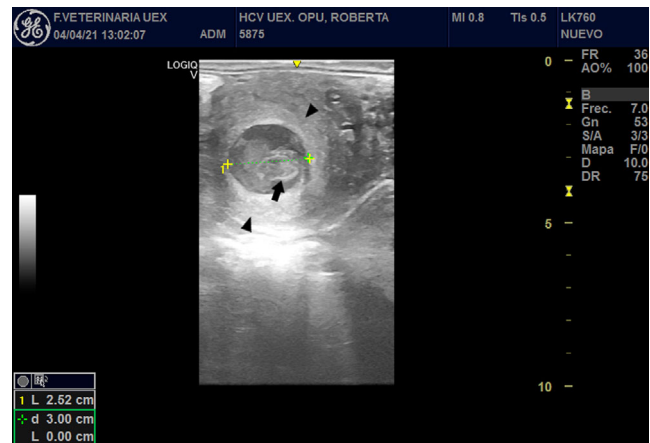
Transrectal ultrasonographic image of the left ovary from 8-year-old crossbred mare (Case 2) showing the ovarian abscess. There is an abnormal structure of 2.5 cm in diameter surrounded by a heterogenous ovarian stroma (arrowhead) containing hyperechoic and heterogenous areas (arrow).
